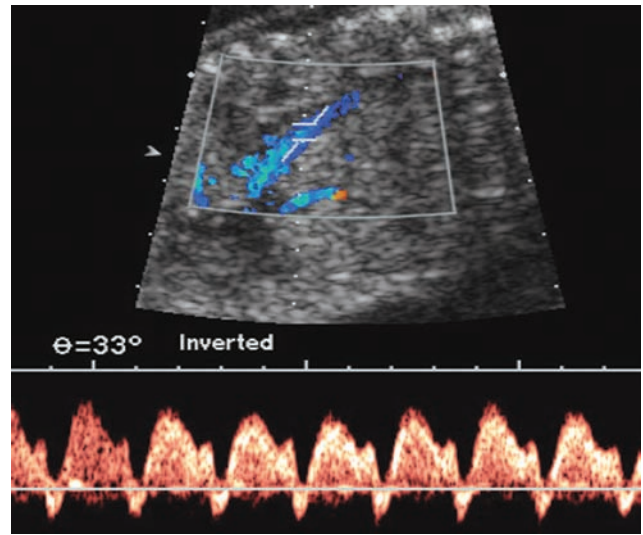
Doppler flow waveforms in the IVC: a physiological slight reversal flow is recorded during atrial contraction (a).
